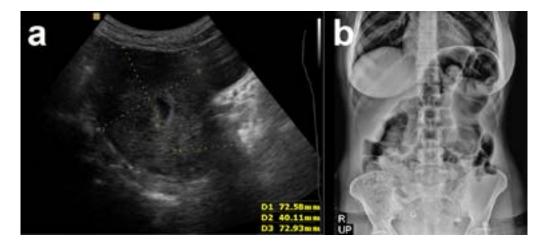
Plain abdominal x-rays
